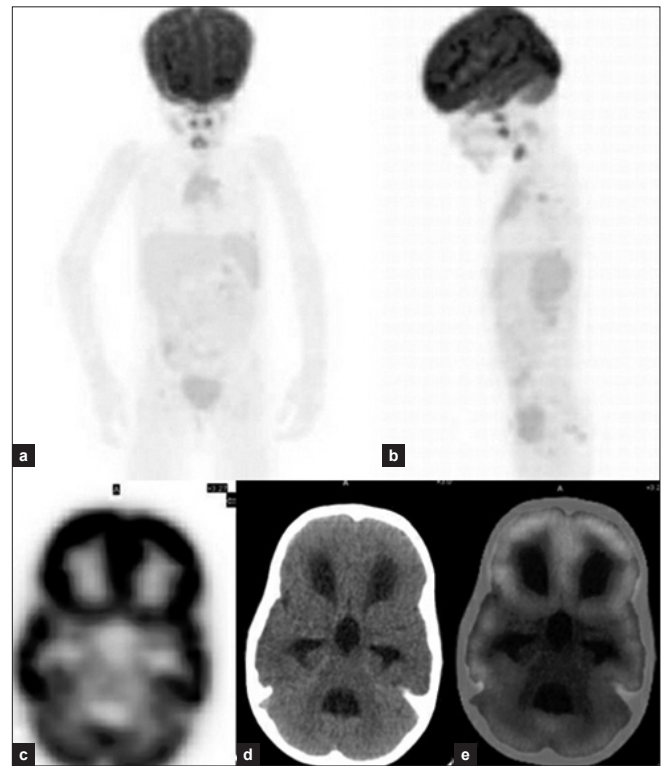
Five-year female of sacrococcygeal teratoma with pulmonary mets sent for evaluation of response to chemotherapy; (a, b) Anterior and lateral MIP; (c, d, e) Axial plain PET, LDCT and fused PET/CT showing moderate communicating hydrocephalus involving B/L lateral, third and fourth ventricles on CT with no FDG metabolism abnormality in the underlying cortex
